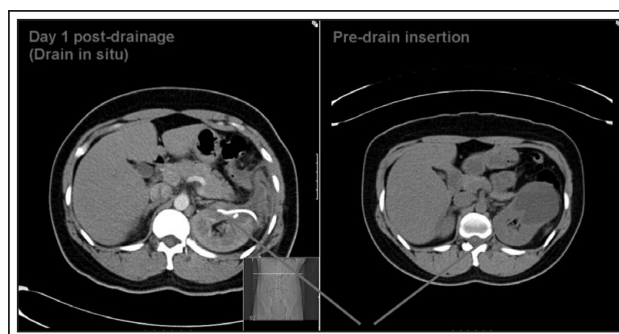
Comparison of contrast CT (left) on day one post-drainage with unenhanced CT (right) on patient's first presentation to A&E, shows significant reduction in the size of the left renal abscess.
